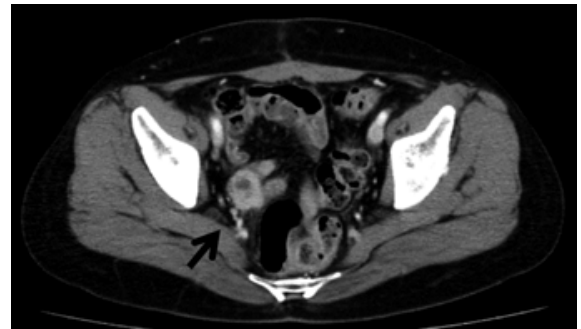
Computed tomography shows recurrence at the right internal iliac lymph node.
